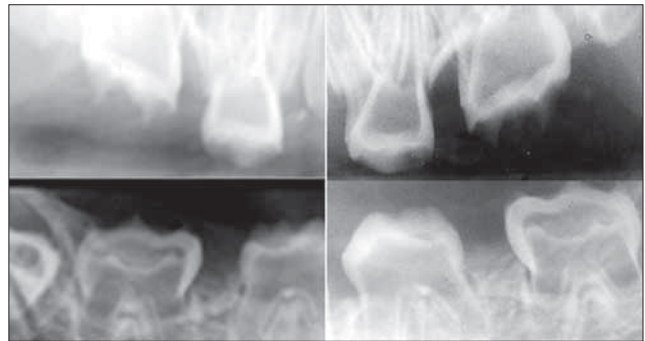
Periapical radiographs of posterior quadrants, demonstrating thin irregular enamel and dentin, and wide pulp chambers resembling "shell teeth".
